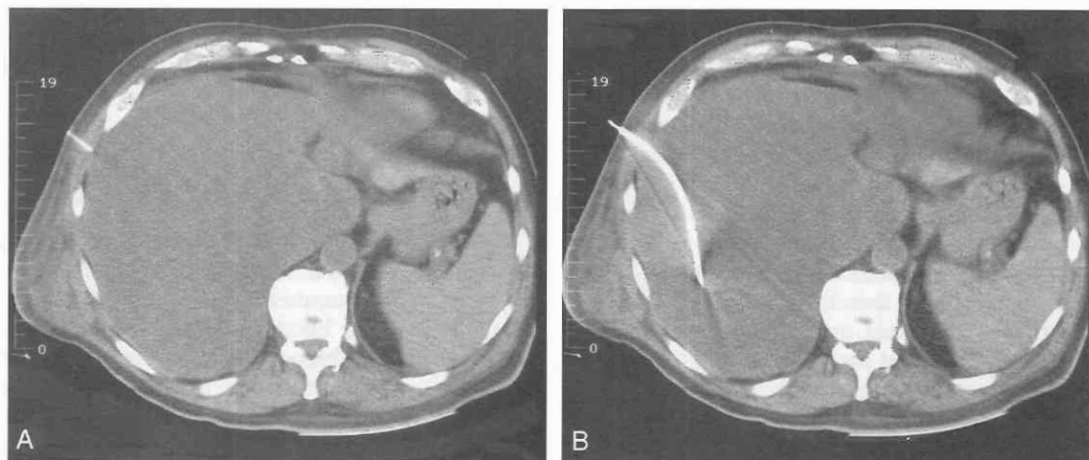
A, CT scan of a former friend (an interventional radiologist) showing a large hematoma in the right chest. Because the patient had refractory leukemia and antibodies to platelets, the platelet level could never be elevated above a total value of 0 to 5. Other clinical services refused to attempt drainage to permit expansion of the lung. A small needle is used along the pathway to infiltrate platelets. (This is not an FDA-approved technique, but it is legal under FDA guidelines.) B, Subsequent scan shows placement of a large catheter in the hemothorax, which was successful and allowed drainage without problems.
